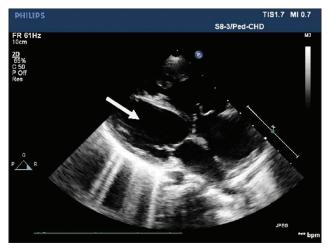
Transthoracic echo image showing spherical left ventricular cavity, indicated by solid white arrow (48 h after starting the patient on continuous positive airway pressure ventilation and levosimendan)
